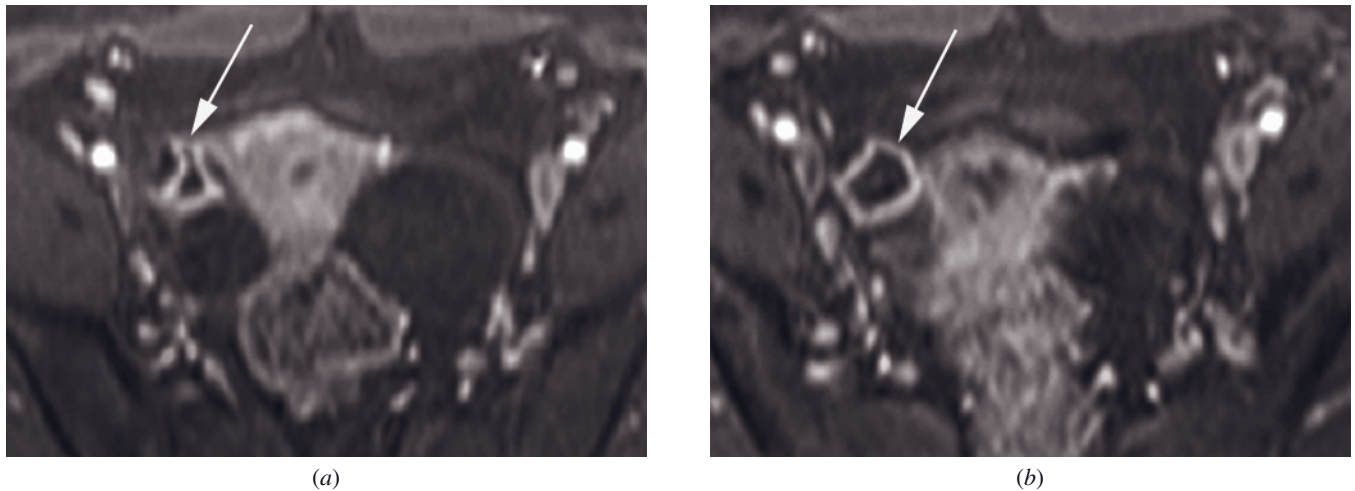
Corpus luteal cyst. Transverse gadolinium-enhanced fat-suppressed T1-weighted gradient-echo images obtained in late arterial phase show an intensely enhancing, irregularly shaped cyst (arrow, *a, b*). Intense early enhancement and thick, irregular walls are characteristics of corpus luteal cysts on MR images.
